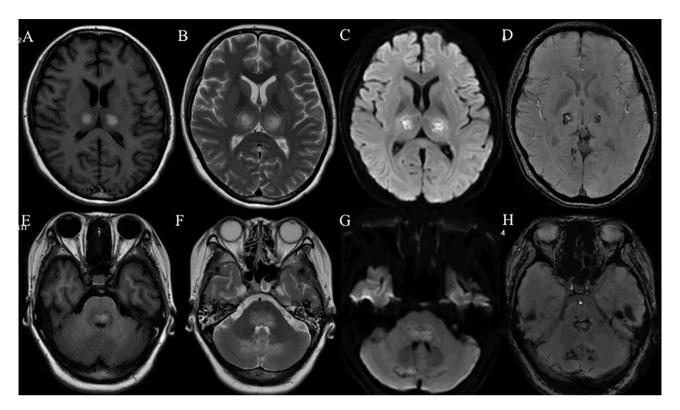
Patient 1 Acute necrotizing encephalopathy in a 25-year-old girl presenting with fever and consciousness disturbance. Axial FLAIR (B and F) and (C and G) T2-weighted images show hyperintensities in the bilateral thalami, PONS, and bilateral cerebellar hemisphere. Axial T1-weighted image (A and E) reveals hyperintensities, suggesting haemorrhages in the thalami and pons. D and H SWI image demonstrating cerebral microbleeds in the bilateral thalami and bilateral cerebellar hemisphere
